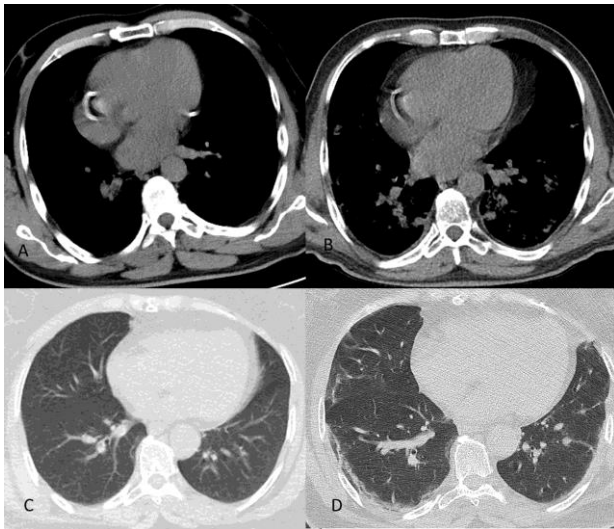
A 59-year-old male patient who presented with cough and fever had normal pleural thickness on the costal surfaces of the lower lobes of both lungs in the mediastinal window on the chest CT performed 7 days after the onset of symptoms (A), while the CT of the same patient performed after 9 days showed consolidation areas in the lower lobes of both lungs and costal pleural thickening in the lower lobes of both lungs (B). A 61-year-old female patient with a history of asymptomatic contact at the time of admission had no COVID-19 finding on the admission CT (C), while the CT of the same patient performed on day 7 due to developing shortness of breathing during the follow-up revealed subpleural curvilinear fibrotic bands and pleural thickening in both lungs.
